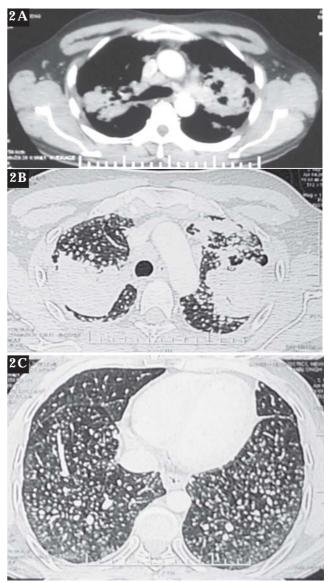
Computed tomography of the chest showing bilateral multiple randomly distributed nodules in upper, middle and lower lobes with progressive massive fibrosis with cavitation in both upper lobes (Left > right).
